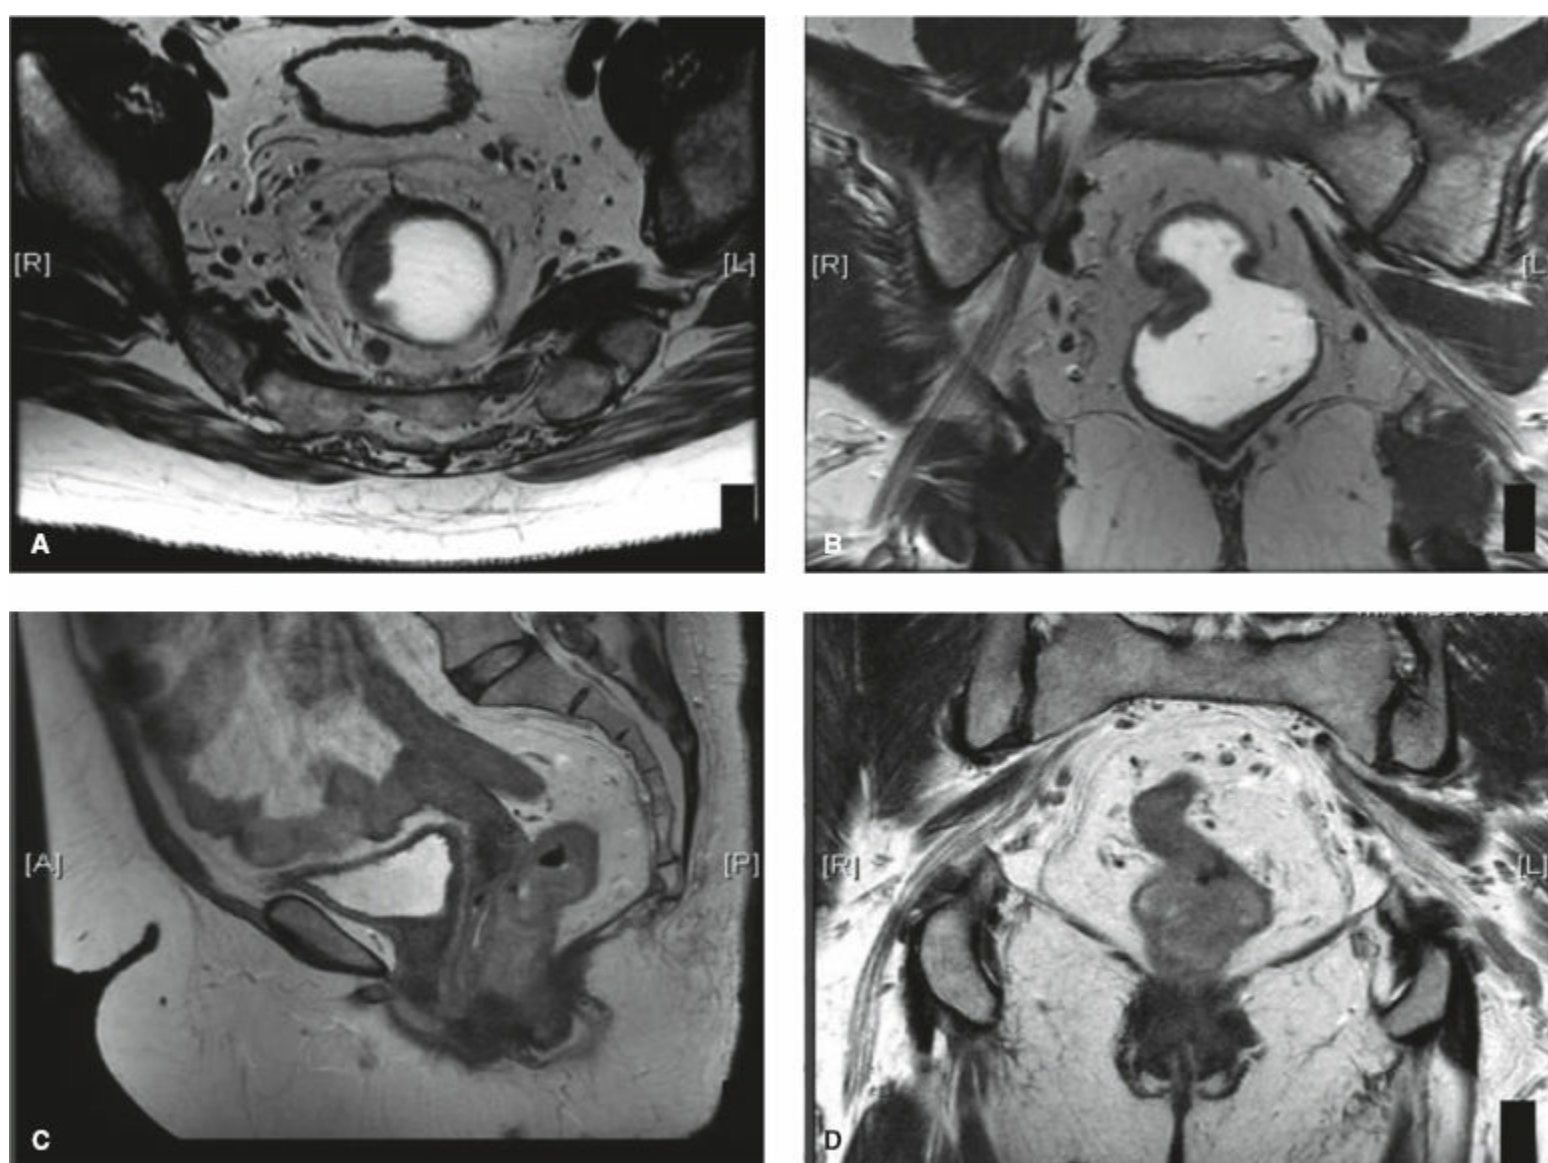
Magnetic resonance imaging. Role in rectal cancer staging.
